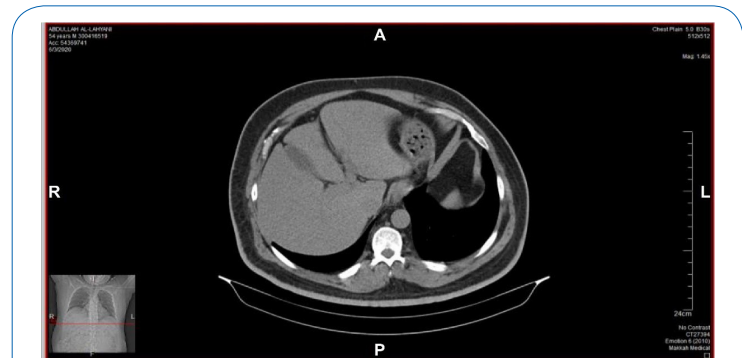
Liver cuts from the chest computed tomography performed two weeks prior to admission does not show any signs of a liver abscess.
